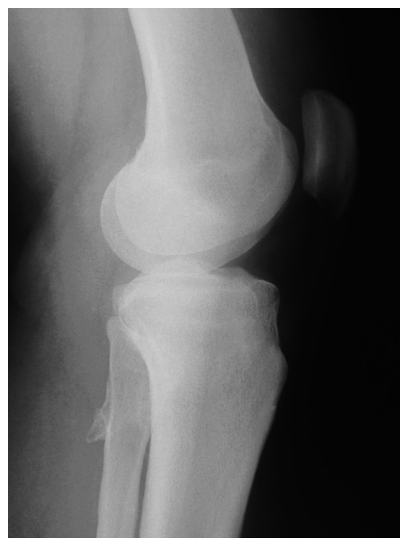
An x-ray scan of the left calf performed 3 years after the initial operation, which shows the recurrence of the osteochondroma of the fibular head
